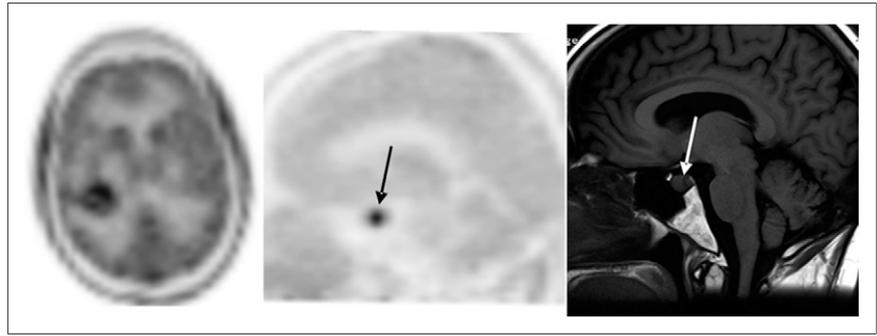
^{18}F -FDG PET scan (left) demonstrating mild ^{18}F -FDG avidity (arrow) in parietal lesion noted on CT (center). PET/CT image coregistration (not shown) revealed no uptake in areas of edema on CT and MR imaging, with subtly increased ^{18}F -FDG accumulation corresponding to described lesion. ^{18}F -FDG accumulation in pituitary (right) on PET confirms that activity is localized to pituitary.
